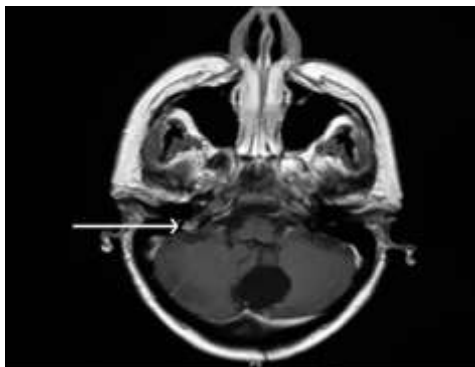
MRI brain including temporal bone showing endolymphatic sac tumour
